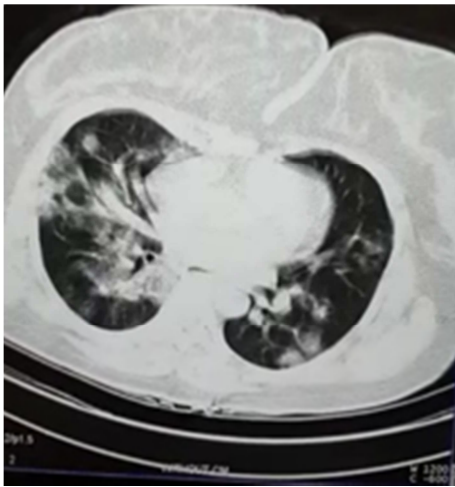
HRCT of the case number 4 neonate's mother with bilateral peripheral consolidation.
